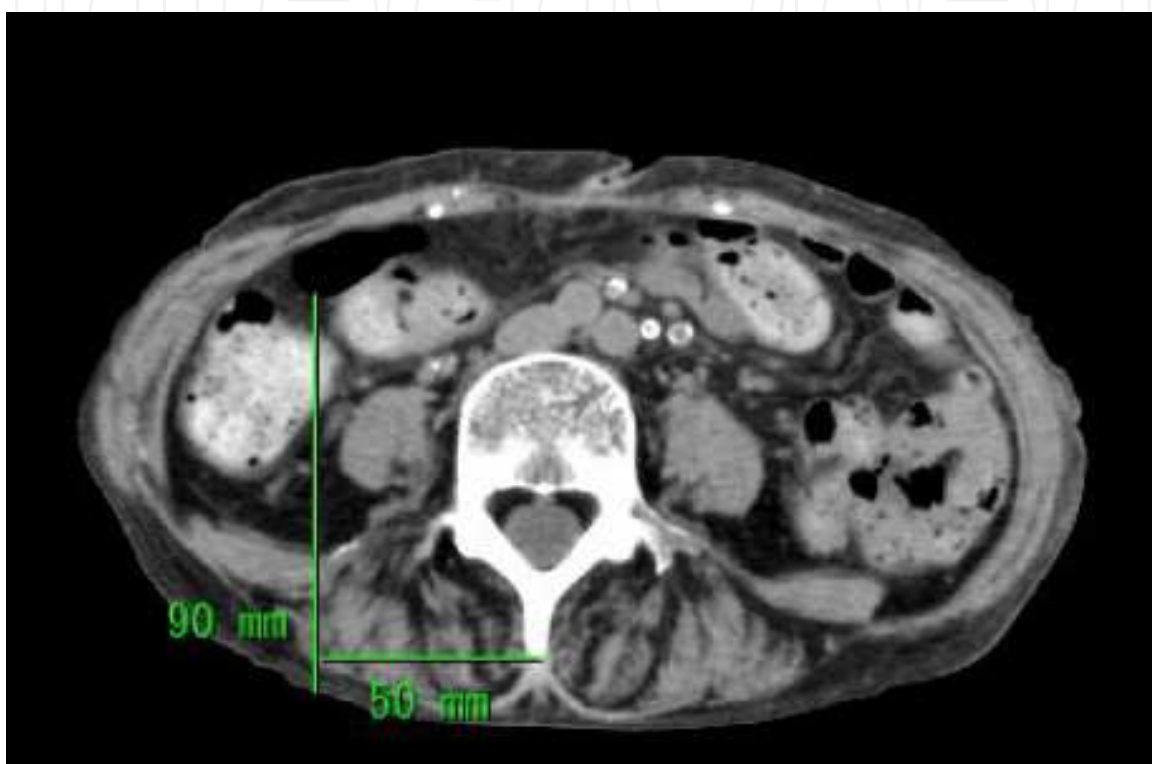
The computed tomography at the 4th lumbar spine from a 74-year-old female.
